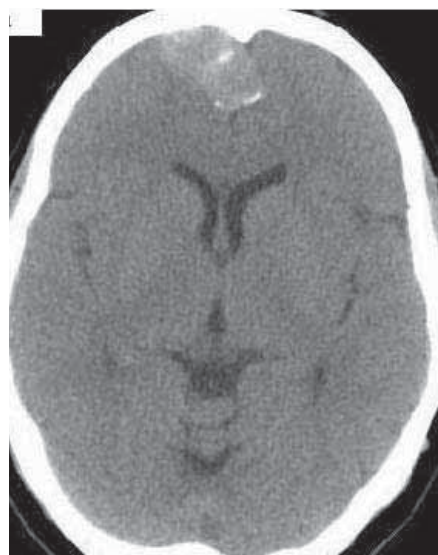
Preoperative CT scan showing right frontal hyperdense lesion, suggestive of meningioma.
